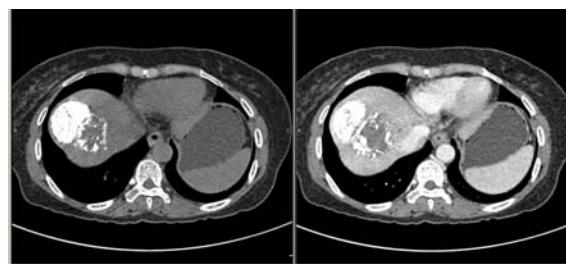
CT scan after TACE for 2 weeks showed absence of lipiodol granule in bilateral basal lung fields
